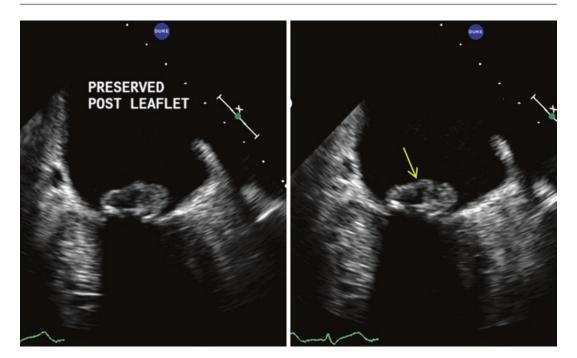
Transesophageal echocardiogram showing the posterior leaflet gathered above the mitral prosthetic ring
